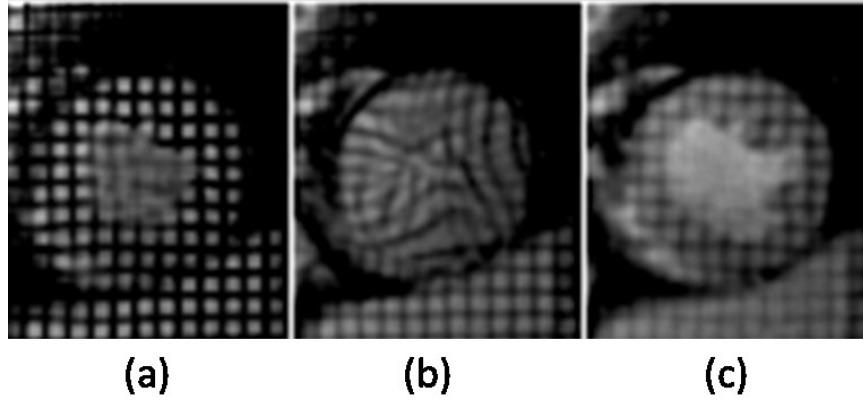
Tagged MRI in one cardiac cycle from (a) ED to (b) ES to (c) ED.
